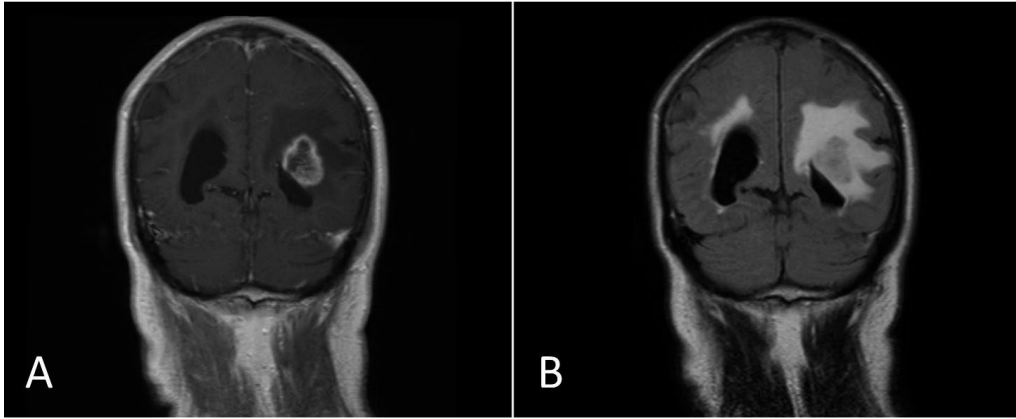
Typical glioblastoma morphology on MRI scans. A T1-weighted postcontrast scan with ring-enhancement, central necrosis and peritumoral edema. B FLAIR scan with hyperintense peritumoral edema. Picture courtesy of Anne Line Stensjøen.
